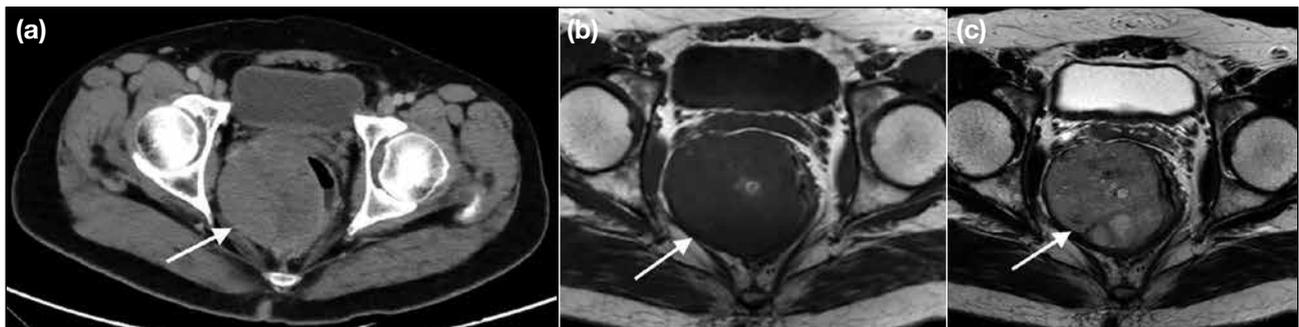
Rectal gastrointestinal stromal tumour in a 48-year-old man. (a) Contrast-enhanced computed tomography showing a heterogeneously enhancing mass with smooth margin arising from the right mesorectum with possible invasion into the mesorectal fascia and right pelvic floor (arrow). (b) T1-weighted and (c) T2-weighted magnetic resonance imaging showing a well-defined eccentric mural mass at right mesorectum. The mass is heterogeneous, T1 isointense and T2 hyperintense relative to muscle.
